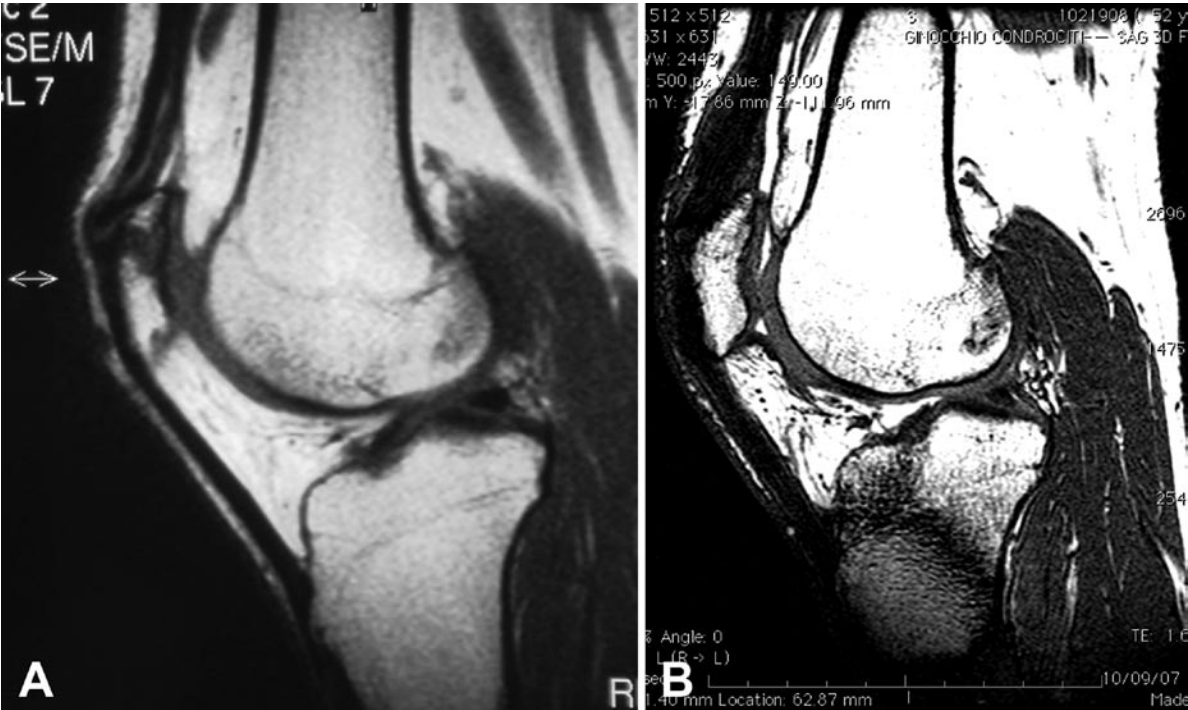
MRI evaluation of a patellar defect before (a) and at 8 months after the osteochondral scaffold implantation (b)
